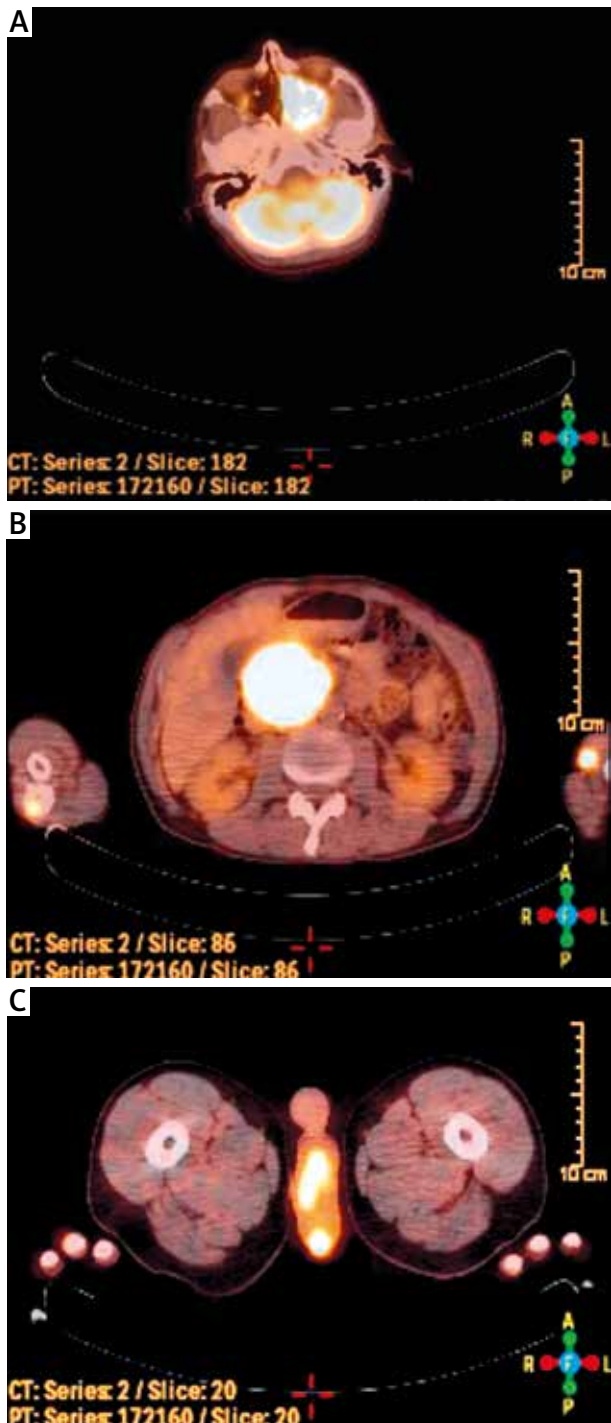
PET/CT fusion images revealed mild F-18 FDG uptake in nasal cavity and paranasal sinuses (A), in the head of pancreas (B) and the testes (C)
